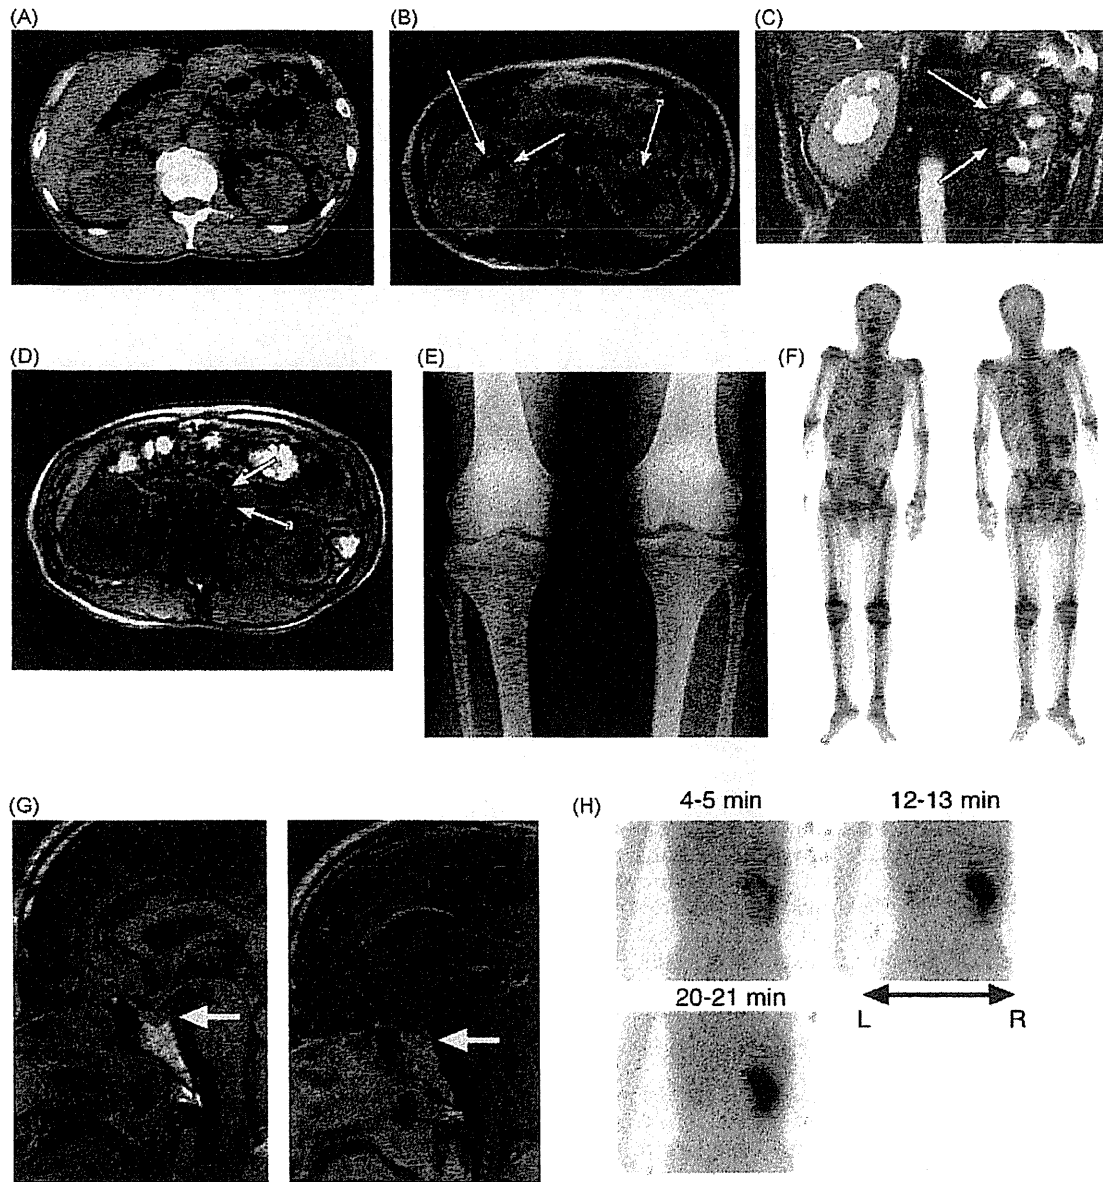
Radiological findings. Abdominal CT (A) and MRI (B) show soft-tissue infiltration in the both renal pelvis (arrows) and associated hydronephrosis. Left renal parenchyma is thinned, suggesting chronic renal impairment. (C) A coronal reformatted enhanced image showing bilateral pelvocaliectasis (arrows). (D) Abdominal MRI scan with periaortic infiltration ("coated aorta") (arrows). Bone radiograph (E) and scintigraphy (F) showing a symmetric medullary sclerosis of the femur and tibia. (G) Brain MRI shows the absence of hyperintensity of the posterior pituitary lobe (arrows) on T1-weighted image, which is also evident after contrast enhancement (right). (H) Renal scintigraphy demonstrates the abrogation of left kidney uptake.
